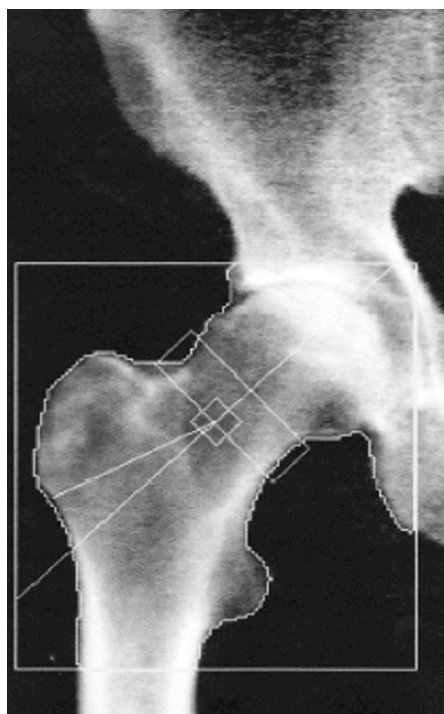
Femoral neck, trochanter, intertrochanteric, total hip and Ward's triangle bone mass density (BMD) measurements with dual energy x-ray absorptiometry (DEXA) of the contralateral hip, serving as baseline measurements six weeks postoperatively. The table is an example of the output derived from the baseline scan.
